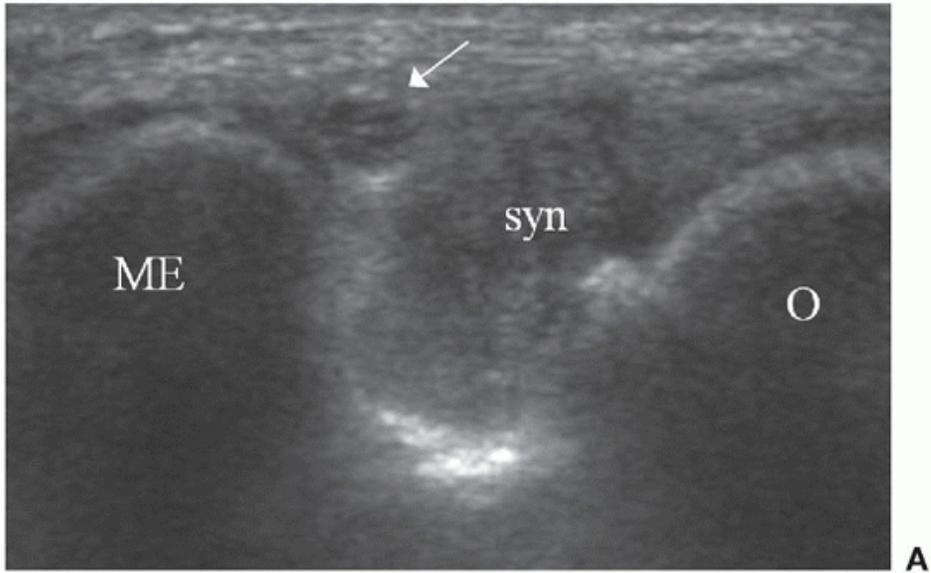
Patient with synovial hypertrophy (syn) in elbow. A: Transverse posteromedial ultrasound scan showing displacement of ulnar nerve (arrow). O, olecranon; ME, medial epicondyle of humerus. B: Power Doppler examination shows synovial hyperemia.
